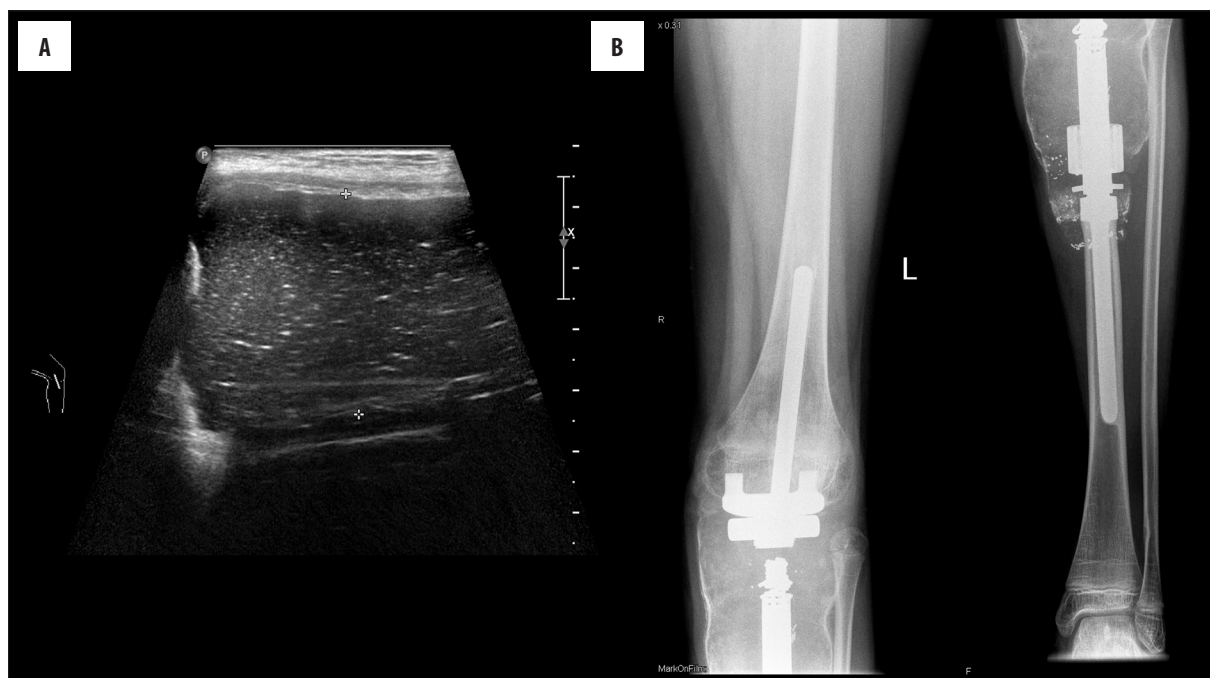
10-year-old boy with osteosarcoma of the tibia one year after implantation of knee prosthesis. (A) Ultrasonography: fluid collection at the level of the knee joint, thickened synovium and soft tissues along the stem of the prosthesis. (B) X-ray: knee prosthesis in the normal position. Thickened soft tissues at the level of the knee joint and along the prosthesis, peripherally calcified. Inflammatory changes were diagnosed.
